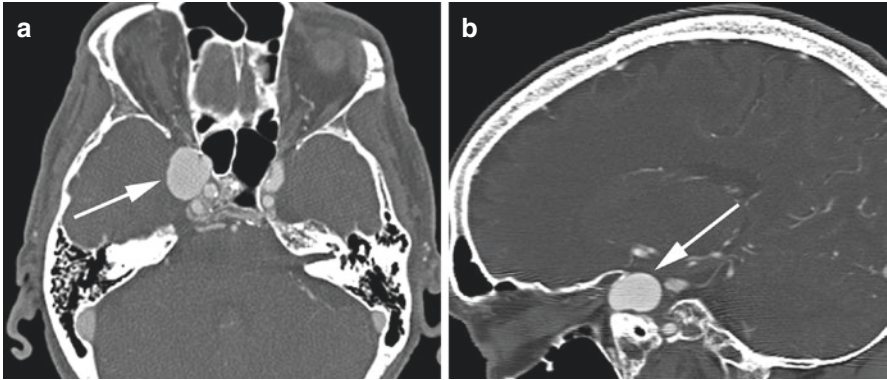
Clinoid internal carotid artery aneurysm. Patient with a clinoid segment ICA aneurysm. Axial (a) and sagittal (b) CTA demonstrates a large aneurysm involving the clinoid ICA segment (arrows)
